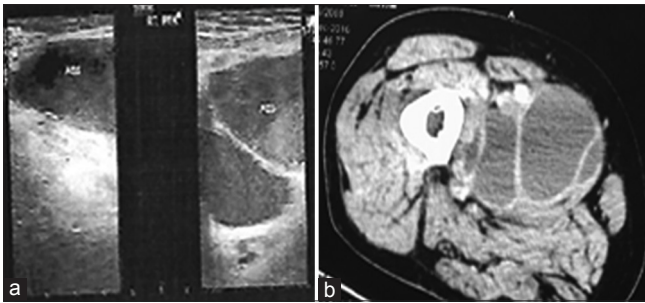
(a) Ultrasound images of the right thigh revealed a large cystic space of 15 cm × 6 cm with internal echoes in medial aspect of the right thigh below the femoral vein extending just below the origin of superficial femoral vessel to mid thigh and (b) computed tomography images of the right thigh revealed a large loculated cystic collection of size 15 cm × 6 cm with internal septation
